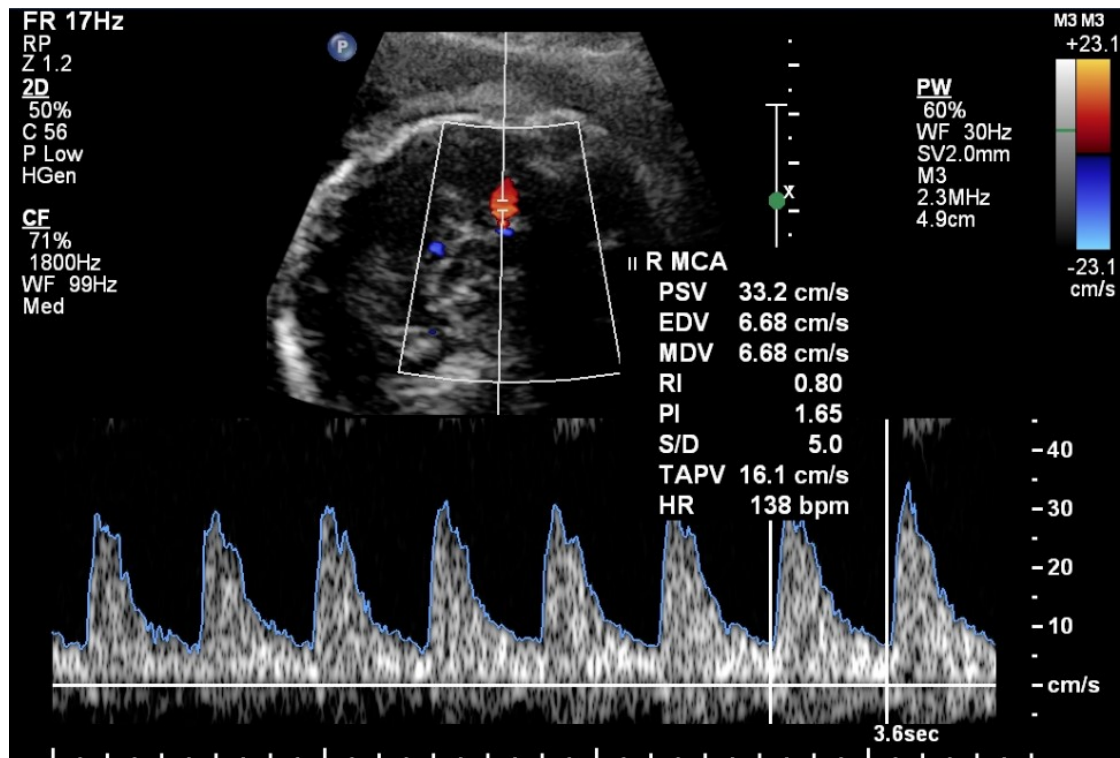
Doppler ultrasound of right medial cerebral artery in a severe case of foetal growth restriction. Abnormal pulsatility index was detected. Anthropometric parameters (head and abdominal circumference; biparietal diameter; expected foetal weight) under 2nd percentile (49).
